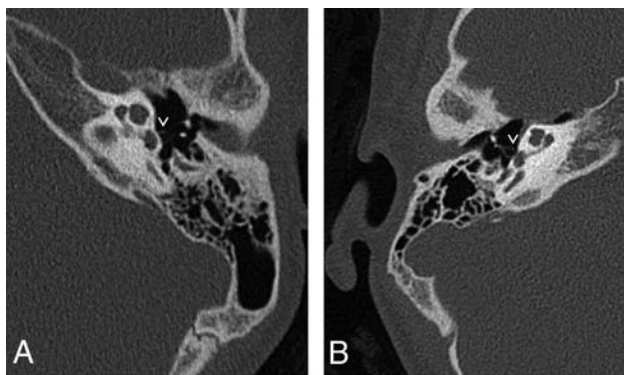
A, Axial CT image of the left mastoid shows a normal stapes superstructure for comparison with B. B, Axial CT image of the right mastoid shows a dense, thick stapes superstructure. The pure tone audiogram of this patient is shown in Fig 5B. The mastoid bones shown in A and B do not belong to the same patient.
